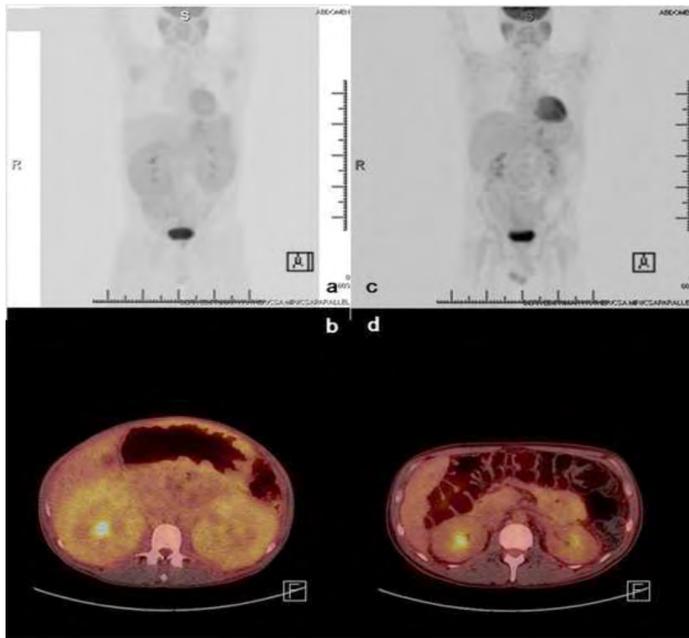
A 41 year-old man with mantle cell lymphoma underwent FDG PET/CT before and after chemotherapy. Before chemotherapy, the MIP image (a) and the hybrid FDG-PET/CT images (b) showed diffused mildly hypermetabolic enlarged lymphadenopathy on both sides of the diaphragm as well as mild diffuse FDG cortical activity in remarkably enlarged
